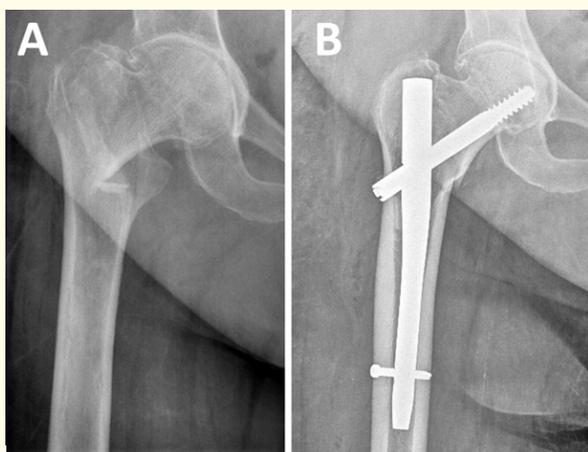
A: Right intertrochanteric femoral fracture; B: Immediate postoperative X-ray showing adequate fracture fixation with Gamma3® (Stryker®) nail.
